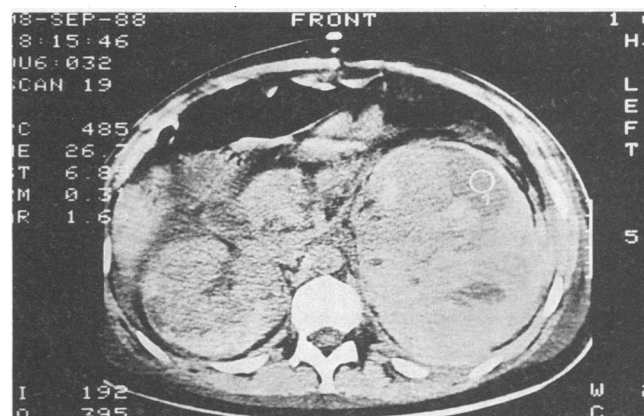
A computed tomographic scan shows massive bilateral renal hemorrhage.
